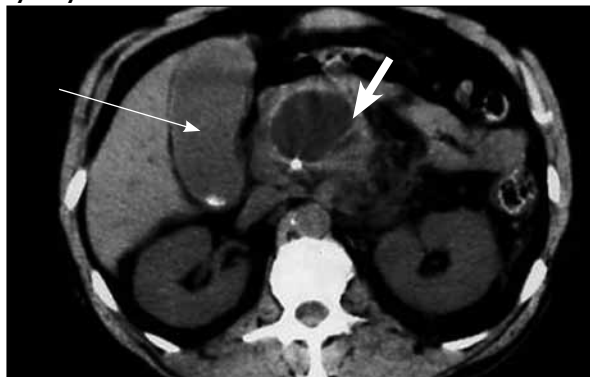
Computed tomography scan in a 46-year-old man with chronic alcoholic pancreatitis: large pseudocyst within head of pancreas (thick arrow) containing focus of calcification. Note the distended gallbladder (thin arrow) (with incidental stone) caused by early bile duct obstruction.
